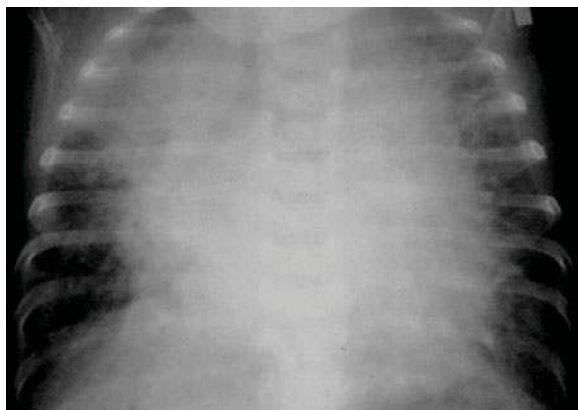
A 1-day-old triplet with valvular aortic stenosis. Note enlarged heart and severe congestion. Echocardiography revealed poor function of the left ventricle
